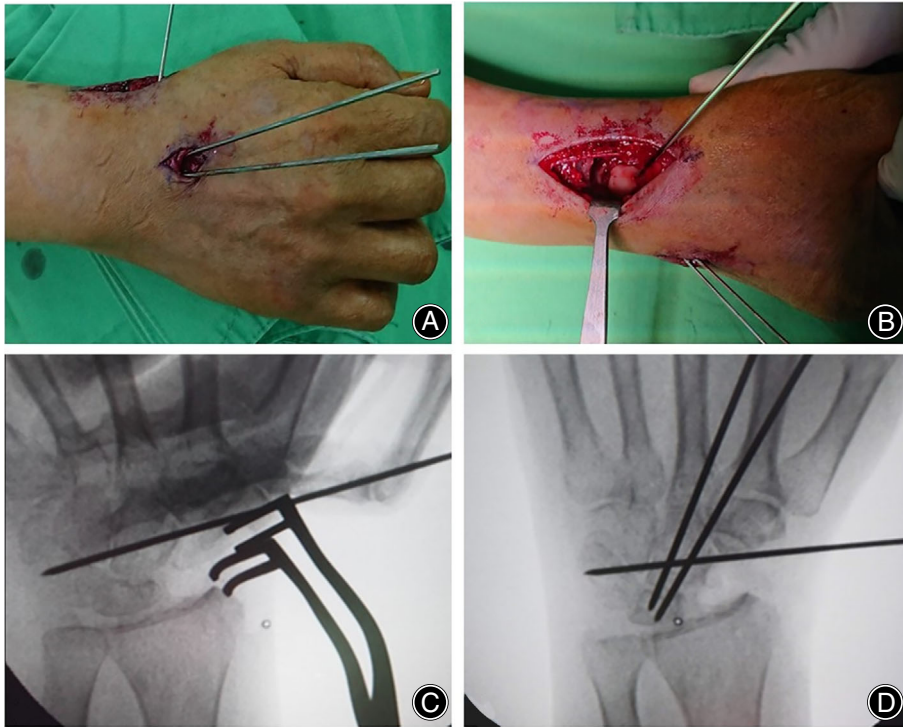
Photographs showing (A) the lateral approach wound and the dorsal wound for capitolunate arthrodesis. (B) Bone graft was stuffed in the capitolunate junction. (C) Radiographs showing temporary capitate-triquetrum transfixation to maintain the reduced relationship of the capitate and lunate. (D) Transfixation of the capitate and lunate.
